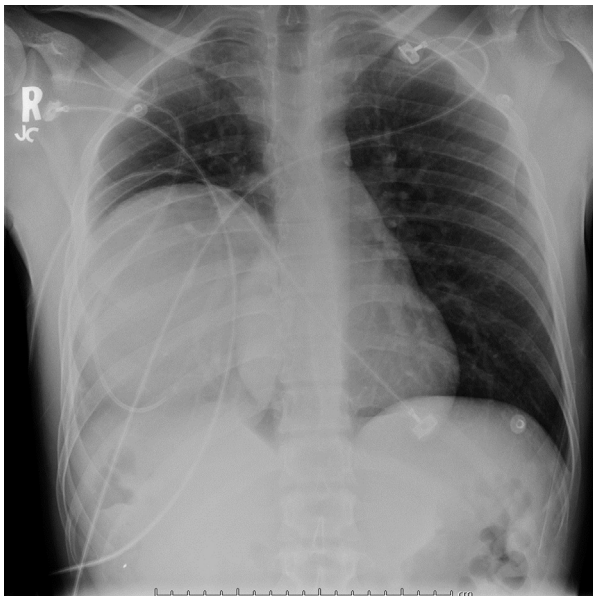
Plain chest radiograph, demonstrating opacification of the right lower lung field.
